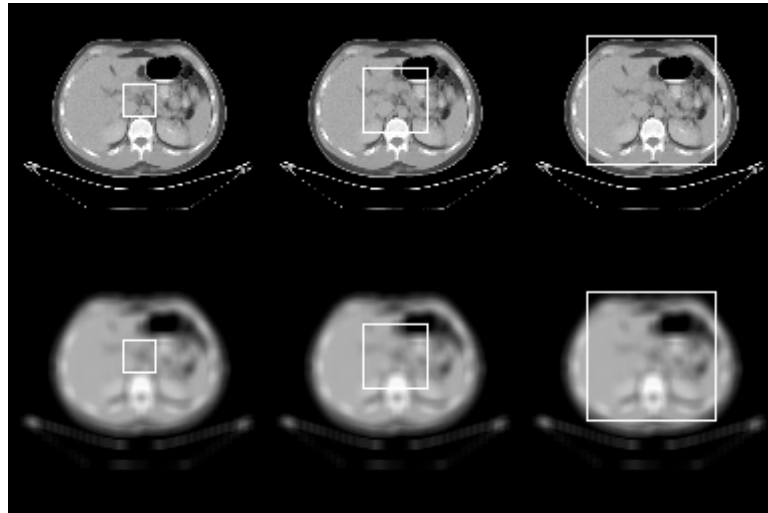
Image blocks (enclosed by windows), with (bottom) and without (top) smoothing, correspond to sizes (from left to right): 16×16 , 32×32 and 64×64 . These sub-images are used to compute MI and SCR as a function of translation along x-axis for two cases: CT-CT and CT-blurred-version-CT.
